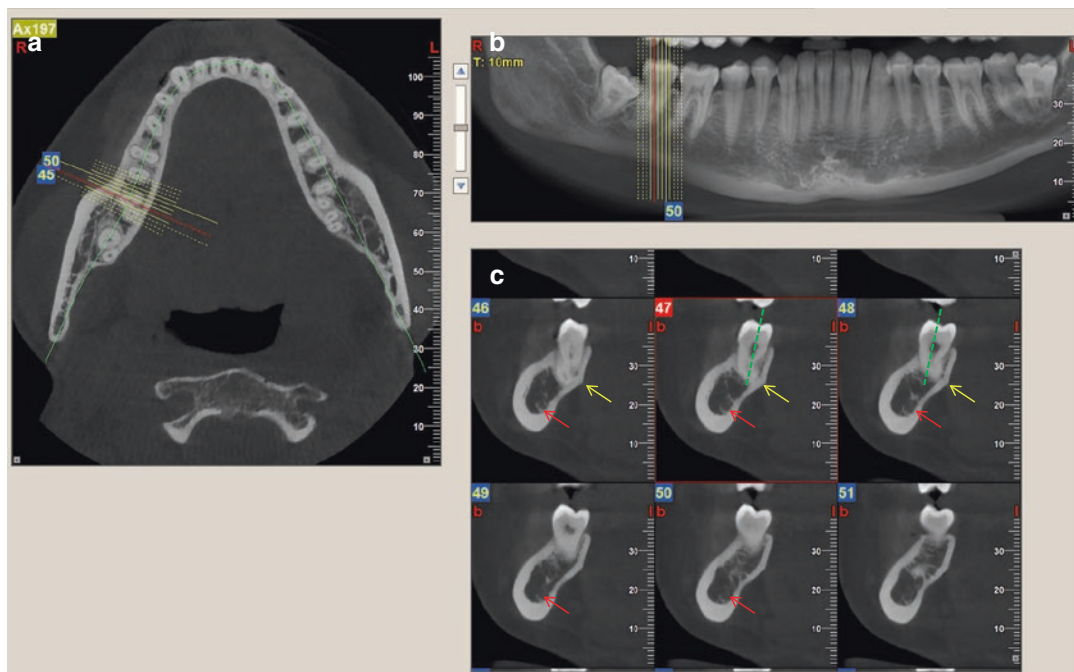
Axial (a), coronal (b), and sagittal (c) CBCT images showing the location of sublingual foraminae (*arrow*). Accessory foramina, like the one demonstrated, have a reported incidence of approximately 65%
